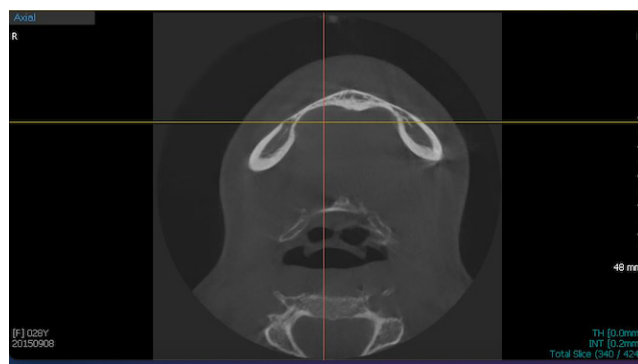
Case 2: Bone depression in the anterior section visualized in the axial plane (CBCT)
